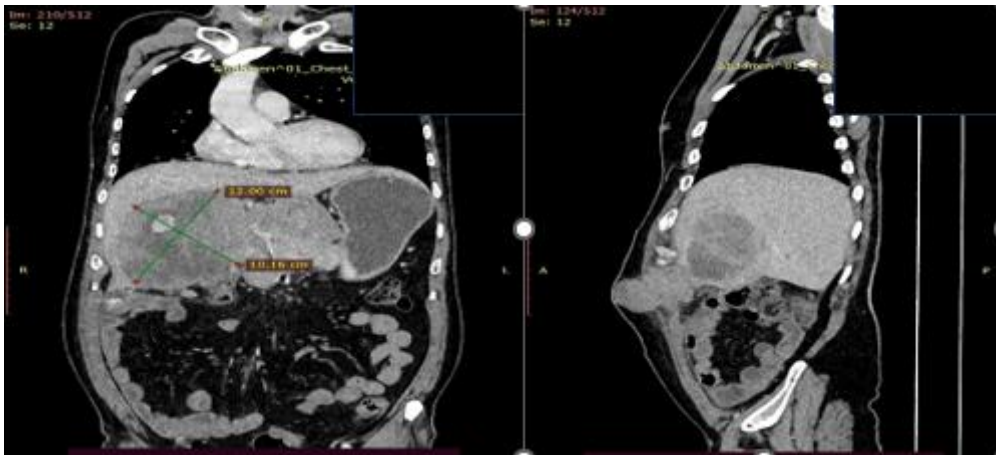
Axial contrast-enhanced CT image demonstrating a large, ill-defined, heterogeneously enhancing mass in the gallbladder fossa with contiguous infiltration into adjacent hepatic segments.
